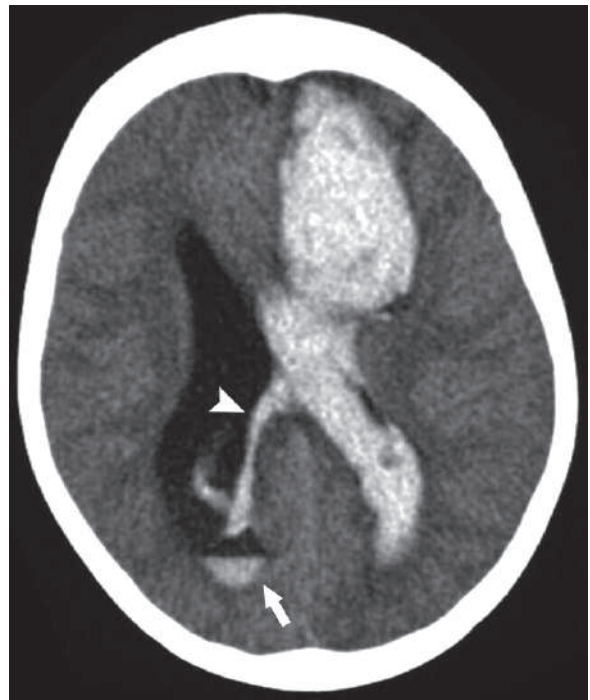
Axial brain CT of a patient with severe intraventricular hemorrhage shows dilated both ventricles due to bleeding, with subependymal (arrowhead) and free (arrow) intraventricular bleedings also seen
